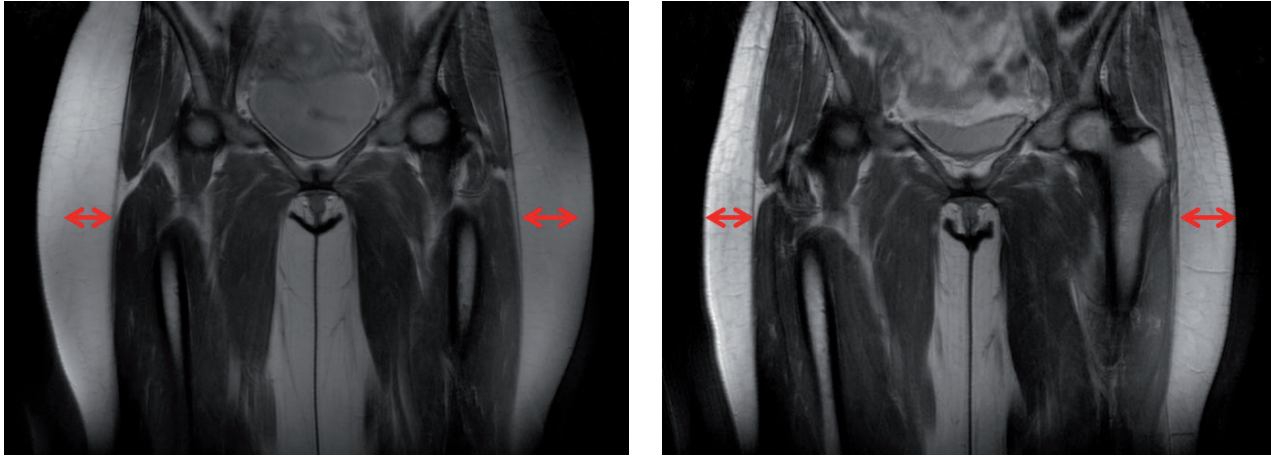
The MRI scans of a 40-year-old female patient showing reduction in subcutaneous fat thickness post treatment (-19.6 mm, right) compared to baseline (left).
